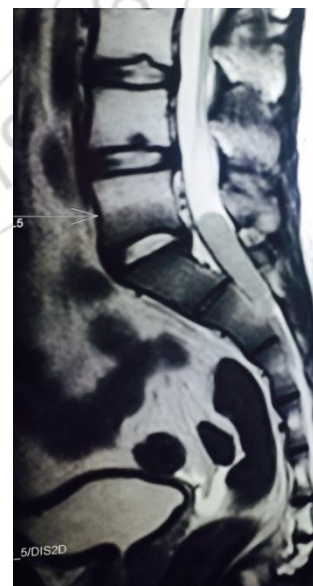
MRI showing lumbo-sacral spine showing intradural lesion in the sacral canal, iso to hyperintense on T2W images, enhancing with contrast
